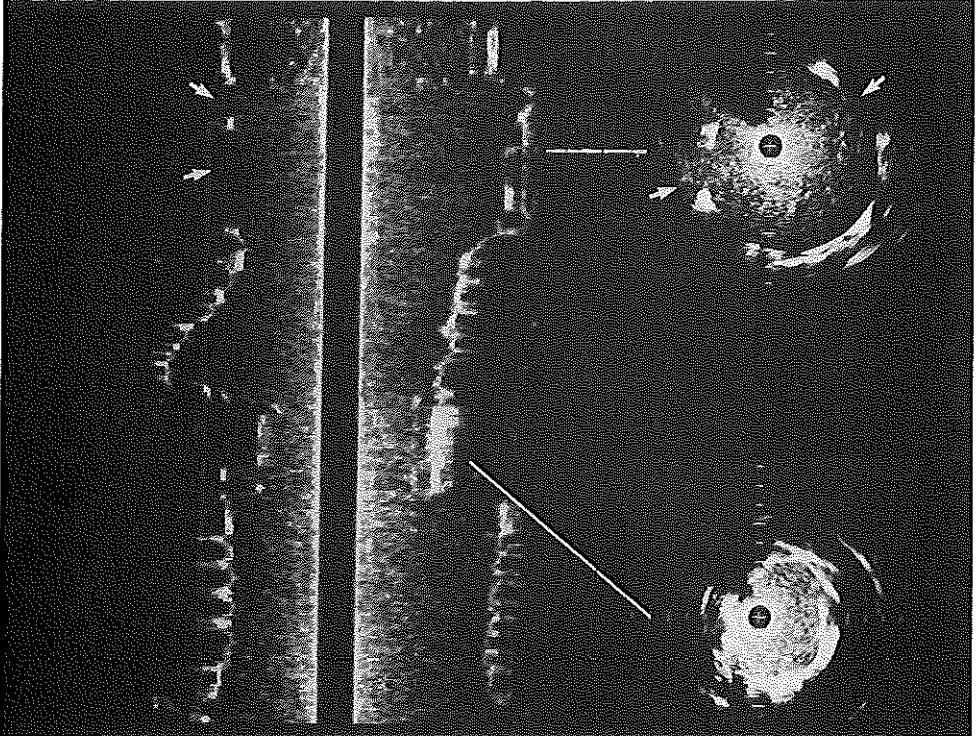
Three-dimensional reconstruction of intravascular ultrasound cross-sections obtained after initial intervention for an aneurysm of the femoropopliteal artery. Right: Upper cross-section shows the too short stent-graft. The arrows indicate the flow through the struts of the uncovered proximal stent into the aneurysm. Lower cross-section shows a ridge within the stent-graft resulting in a stenosis.
